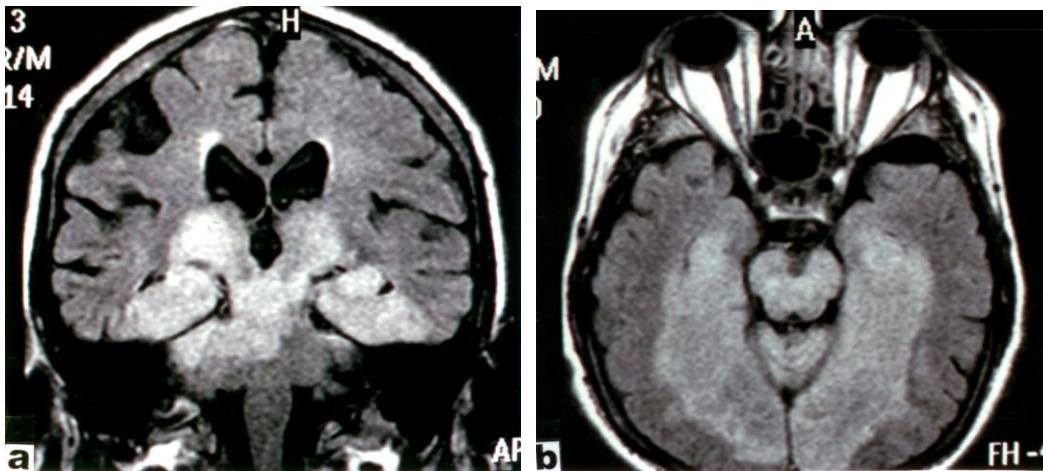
A 56-year old men who presented with a sudden onset of coma and fever. Coronal (a) and axial (b) T1-weighted magnetic resonance imaging (MRI) scans revealed edematous, demyelination symmetrically changes infra-and supratentorial which involve, entire midbrain, both thalamic formations, bilateral basal ganglia, two-side temporo-occipital convolution and hippocampus, determined by encephalitis. After 9 days of coma the patient died.
